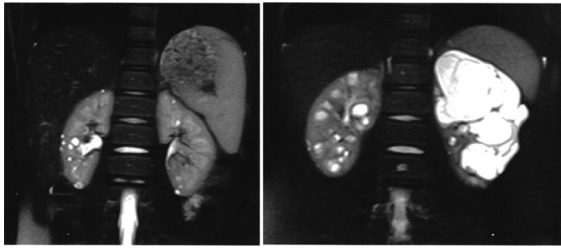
Representative T2-weighted coronal MRI images from two male participants, each 12 years of age, demonstrating heterogeneity of renal cystic disease.
